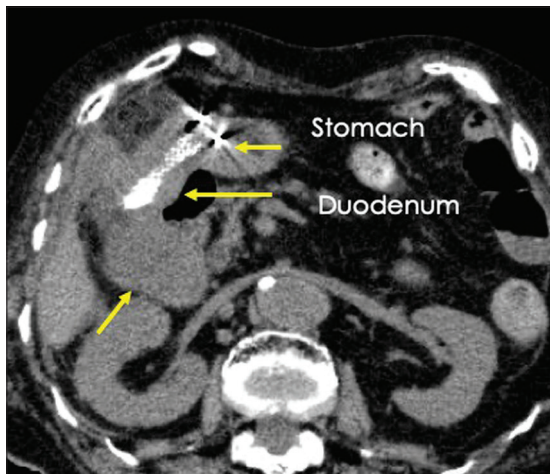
Computed tomography reveals double puncture of the duodenum and stomach
